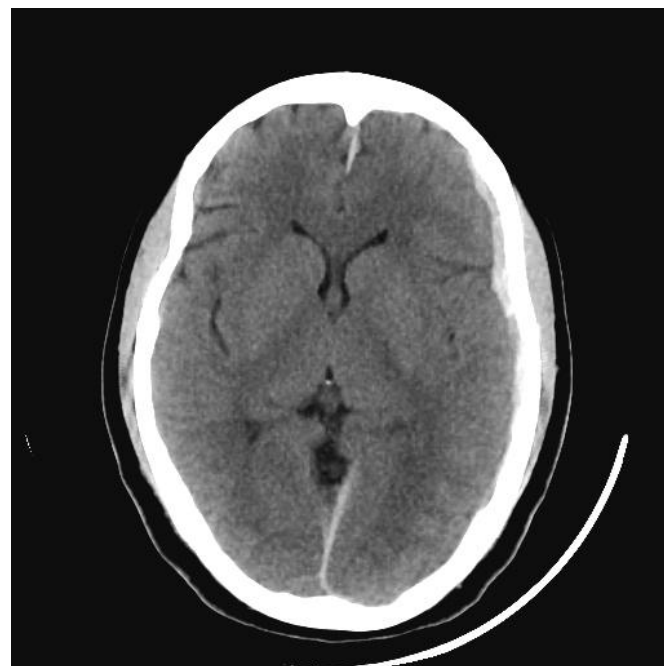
1 non contrast CT brain show acute left fronto parietal convexity subdural haematoma with interhemispheric extension.
